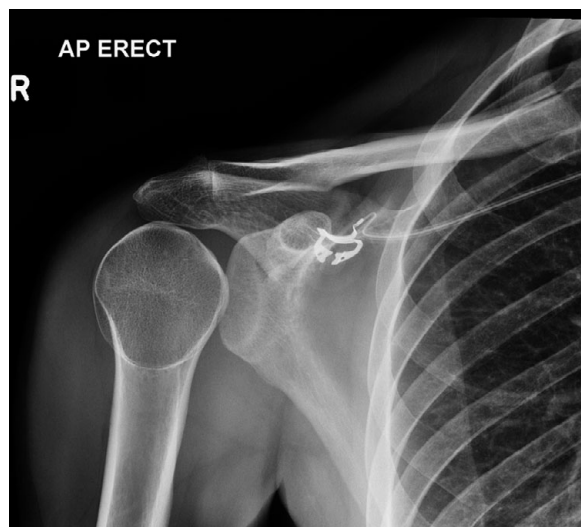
Anteroposterior (AP) radiograph right shoulder
